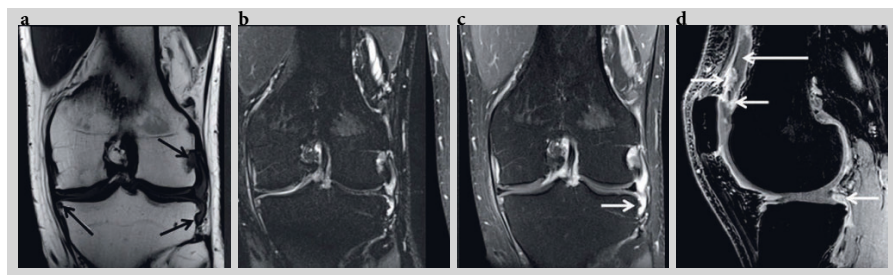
Knee of patient with rheumatoid arthritis. (a) Coronal T1-weighted turbo spin echo; (b) short tau inversion recovery (STIR); (c) T1-weighted with fat suppression post-contrast; (d) T1-weighted 3D gradient echo fat suppressed post-contrast sequences, obtained in a 3T MRI unit. Erosion is seen intracapsularly in the 'nude' area at the lateral femoral condyle, as well as at the lateral and medial tibia (black arrows in a). The post-contrast images (c, d) visualize synovitis (short white arrows) and joint effusion (long white arrow).
